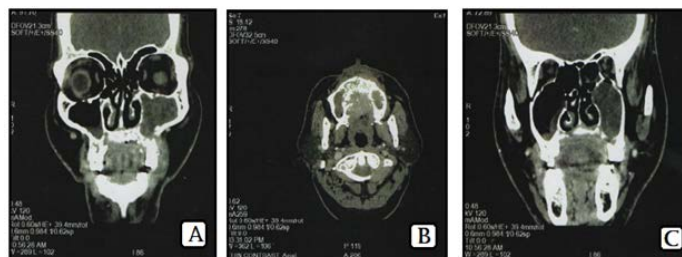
MRI of the face showing radio-opacity with thickened sinus lining involving left maxillary sinus & osteolytic activity on left anterior maxillary region in a patient diagnosed with mucormycosis.
